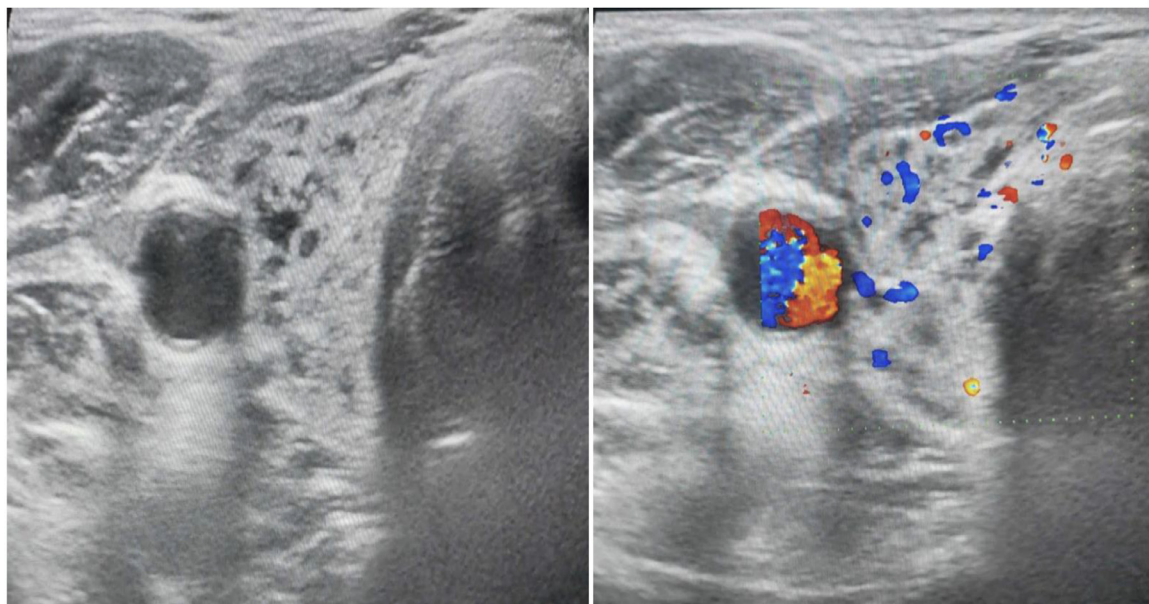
Thyroid ultrasound with Doppler showing increased vascularity in a normal-sized gland.
